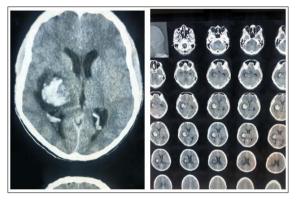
Shows Axial CT scan series
